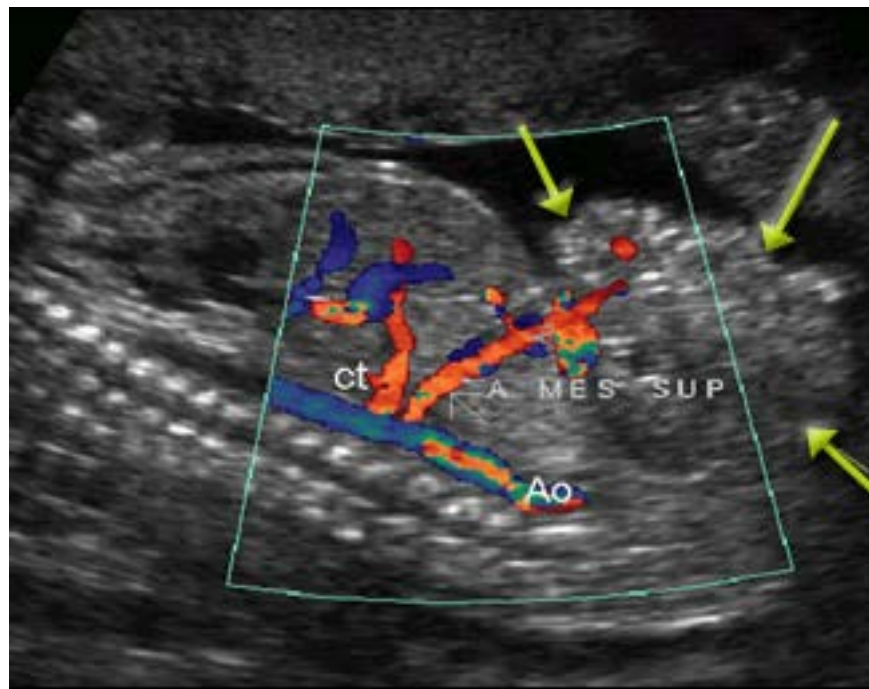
Doppler study of Mesenteric vessels
